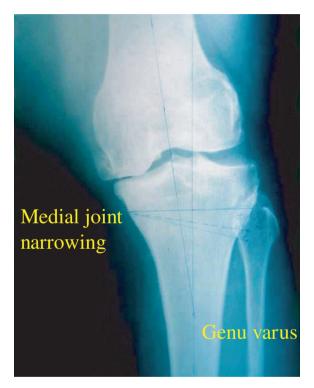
Radiograph of OA knees showing osteophyte formation, subchondral sclerosis and medial joint space narrowing. Radiograph courtesy of Mr John Chen, Dept of Orthopedic Surgery, Singapore General Hospital.
